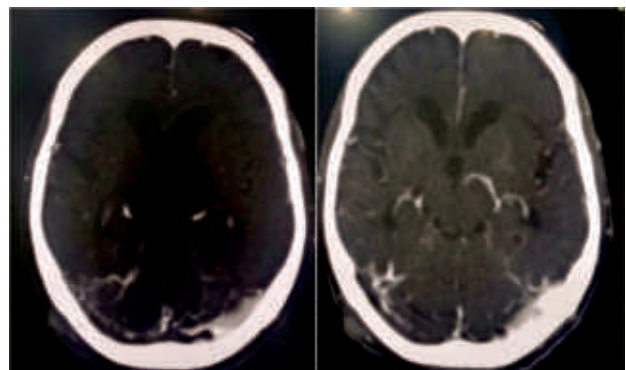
CT Venogram of patient showing sinus thrombosis in right transverse and sigmoid sinus and left transverse sinus
